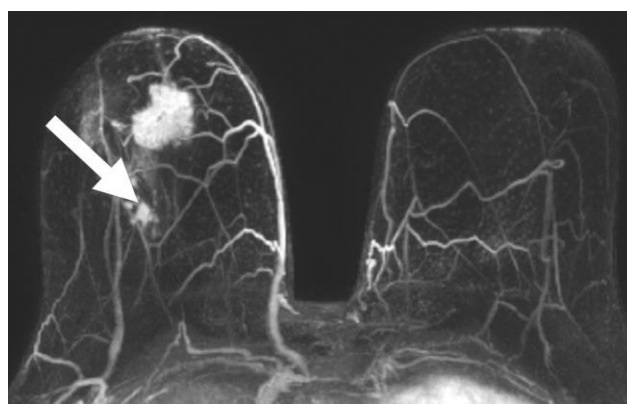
Example of a patient with an index breast cancer (infiltrating ductal carcinoma, IDC) and an additional lesion detected on the preoperative MRI (arrow). The image shows a maximum intensity projection of the first postcontrast T₁-weighted MRI minus the precontrast T₁-weighted MRI. Computer-aided diagnosis (CAD) classified the additional lesion (BIRADS 4) as malignant with predicted probability of malignancy of 88%. The lesion was confirmed on pathology as IDC.
